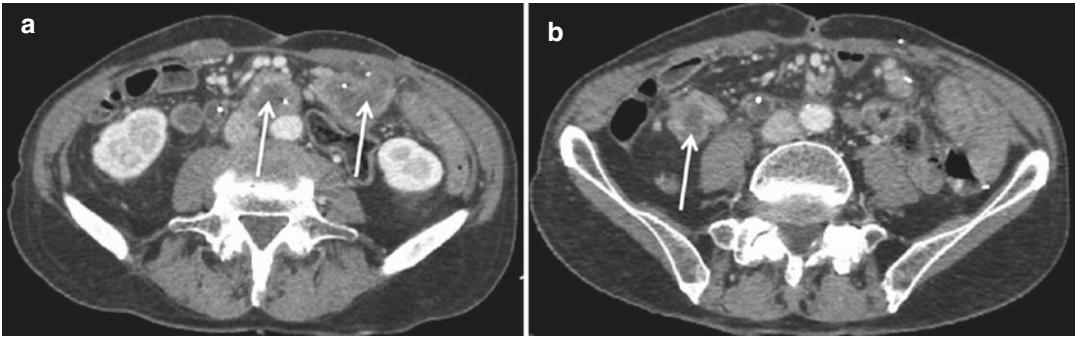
Axial contrast CT demonstrating large nodules involving the mesentery (a) and a nodule within the small bowel serosa in a patient with colon cancer carcinomatosis (b)
